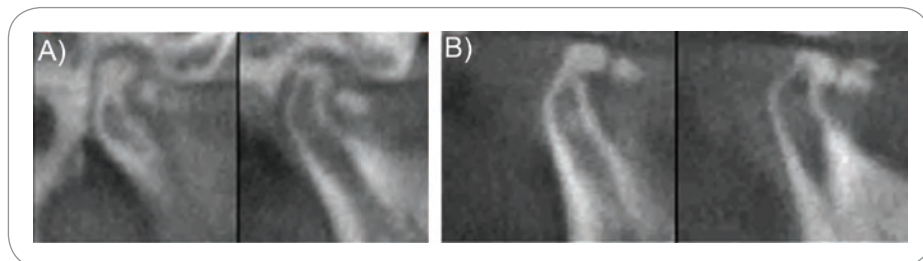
Synovial chondromatosis on lateral CBCT sections in closed (A) and open (B) position showing calcifications within the joint space that follow the condylar movement.
